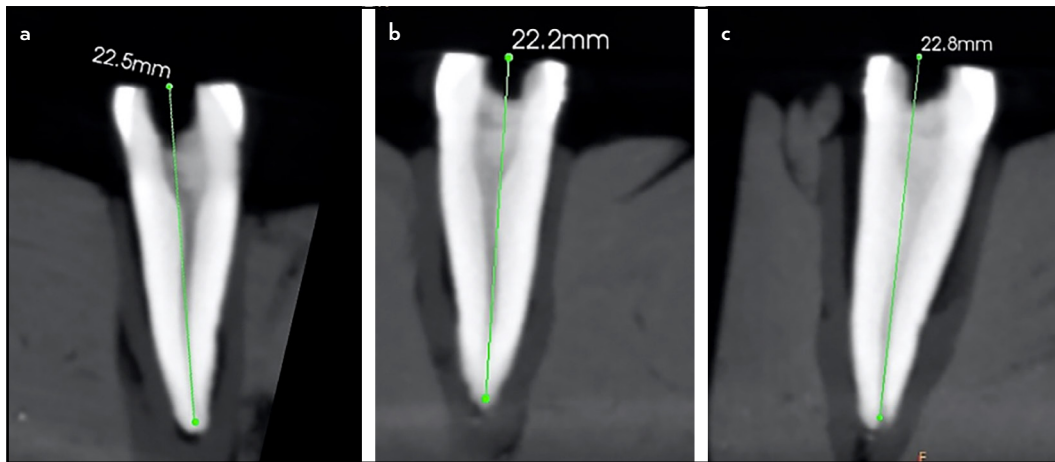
Determination of the working length of a tooth by (a) CBCT at FOV of 5×5 cm, (b) CBCT at FOV of 5×8 cm and (c) CBCT at FOV of 8×9 cm
